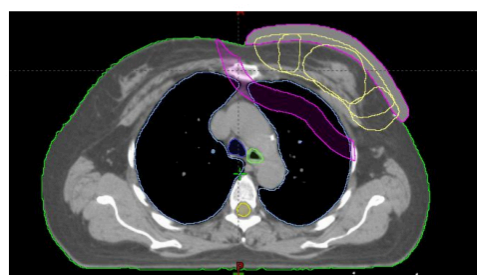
Auxiliary structures: Ring and surface on the modified CT
